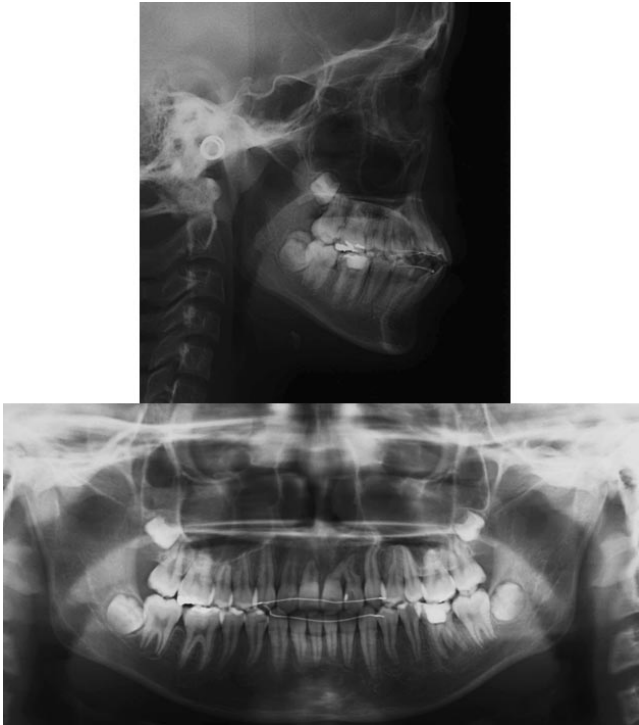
Cephalometric and panoramic radiographs after treatment (13 years six months old).
